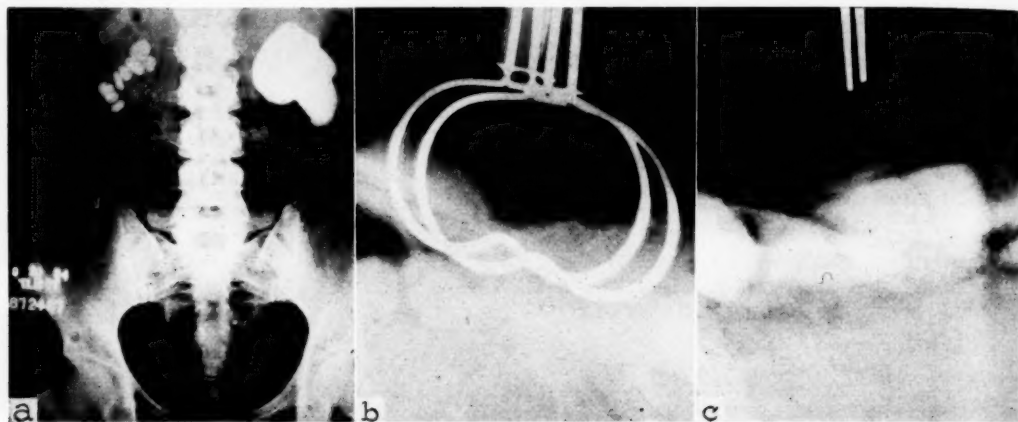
The patient was a woman aged forty-two years who had bilateral nephrolithiasis. Pelviolithotomy, nephrostomy and a plastic operation on the left kidney, as well as right pelviolithotomy were performed. *a*, Preoperative roentgenogram showing bilateral renal calculi; *b*, roentgenogram of left kidney taken at time of operation and showing no further shadows; *c*, roentgenogram of right kidney taken at operation and showing no further shadows.
